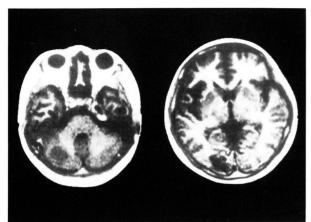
T2-weighted MRI on the second day of admission reveals high intensity areas in bilateral occipital areas and left cerebellum. T1-weighted images (IR) demonstrated abnormal areas as low intensity areas. MRI scans were performed with T2-weighted spin echo (SE2000/80) sequence and T1-weighted images (IR; inversion recovery, 1500/44/300) in the axial plane used by a Sanyo SNR15P (permanent magnetic, 0.15T) system (Osaka, Japan).
